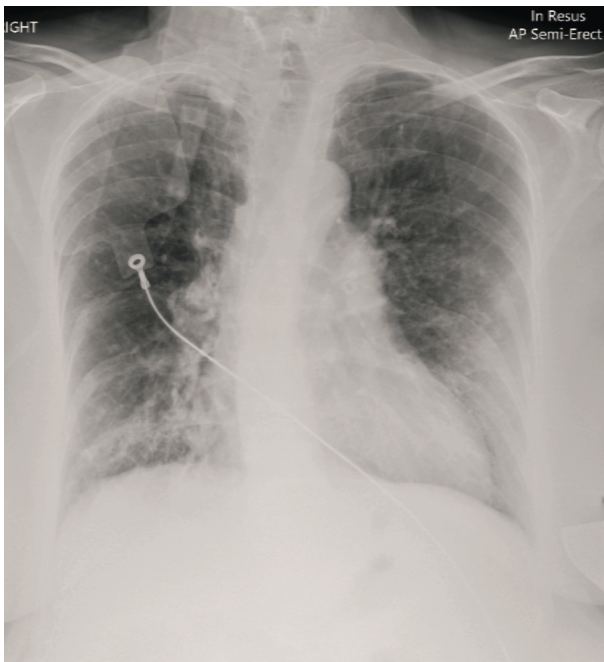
Chest X-ray taken on admission showing airspace shadowing in the right lower zone consolidation and the presence of kyphoscoliosis.
